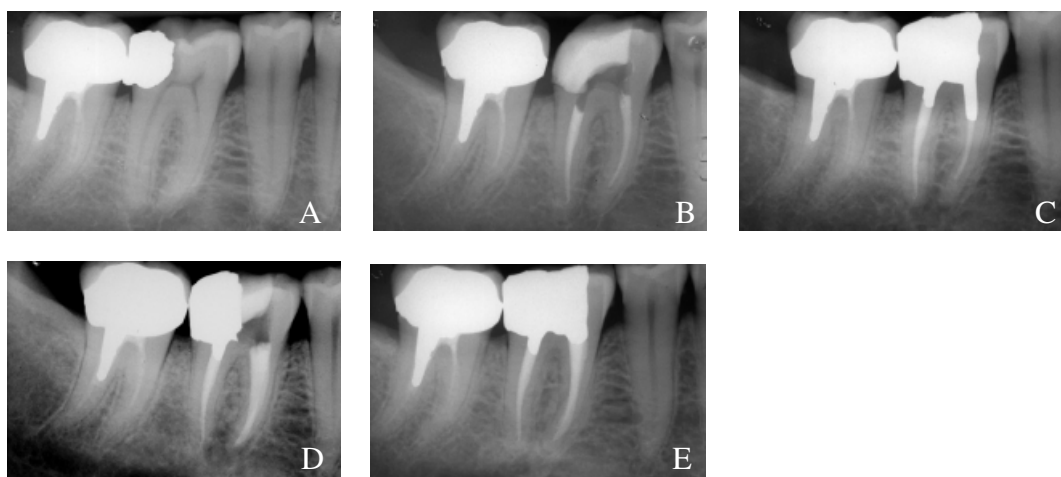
Pulpectomy of tooth #46 because of secondary caries into the pulp. (A) Preoperative radiograph. (B) Immediate postoperative control. (C) One-year follow-up. Patient presents with a symptomatic tooth (pain and percussion sensitivity). Radiograph shows an osteolytic lesion associated with the mesial root. (D) Postretreatment radiograph. (E) Two-year postoperative control. Tooth is comfortable and shows normal periapical bone structures.
